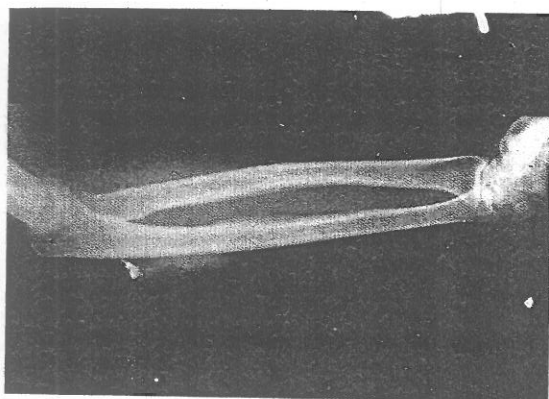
X-ray of the right forearm showing periosteal thickening and translucency of the medullary region and calcification in the tumor area.
